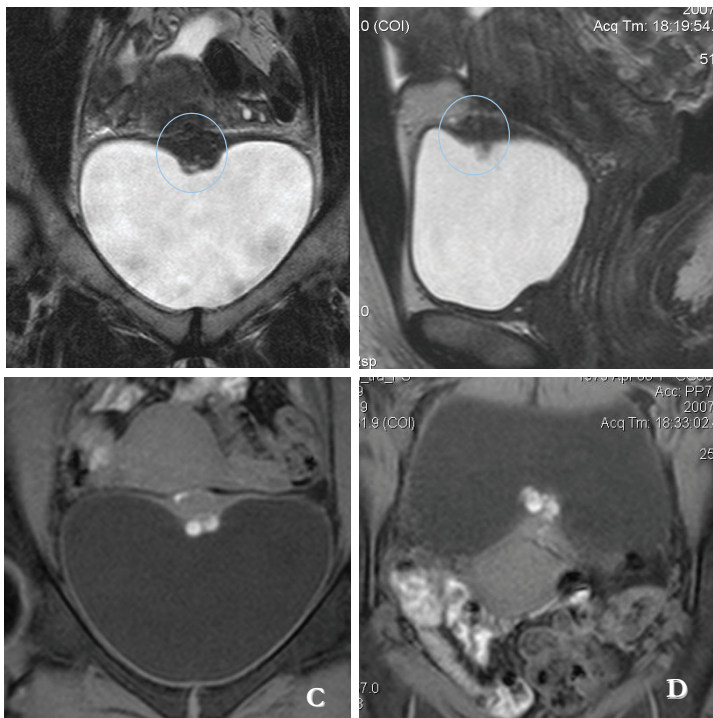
Coronal (A) and sagittal (B) T2-weighted images showing localized bladder wall thickening in the anterior upper bladder wall (blue circles). On fat suppressed T1-weighted coronal (C) and axial (D) images some high signal intensity intra-lesion spots indicating recent haemorrhage.
